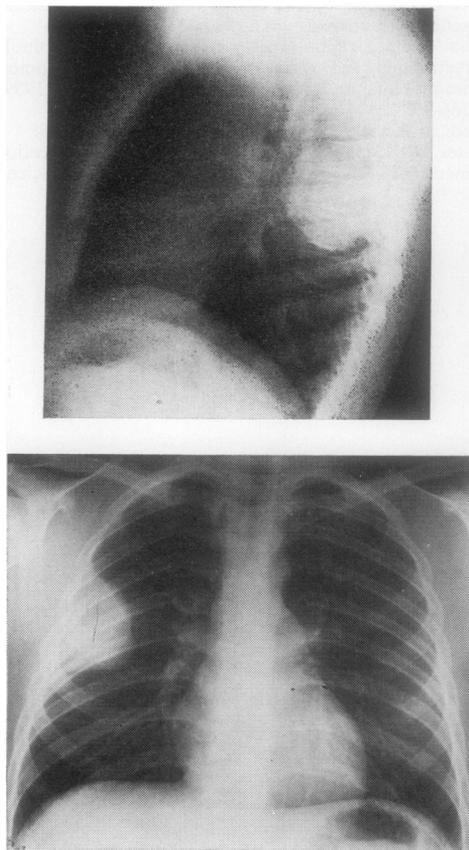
P—A and lateral chest radiographs.
